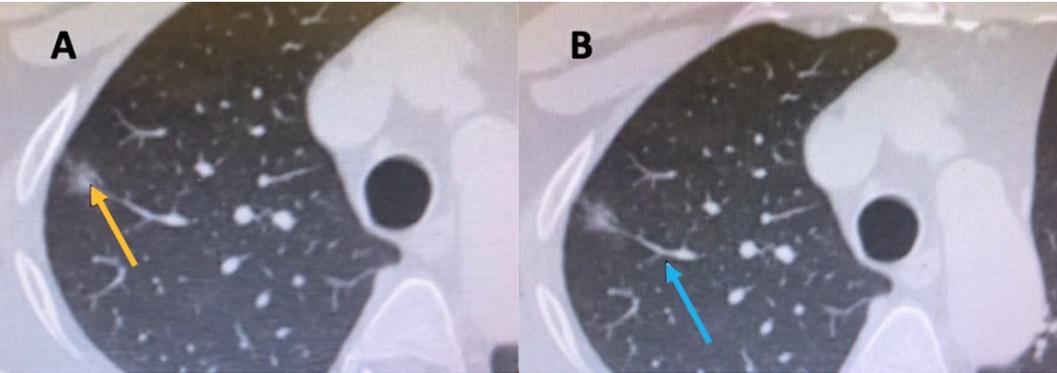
The “Vessel Sign”. CT image in the axial plane showing a subsolid peripheral nodule (yellow arrow) without a bronchus sign (A). However, a pulmonary artery branch was identified (blue arrow) leading to the nodule (B).
